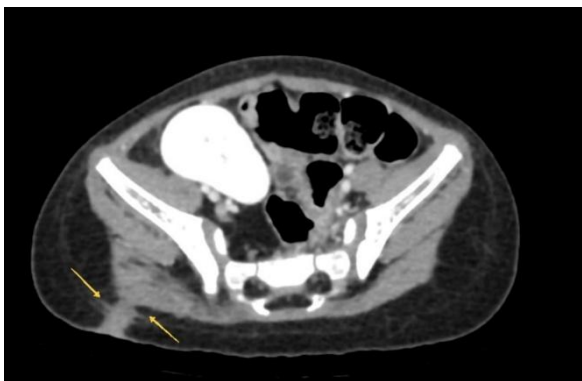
CT showing tract from skin extending into right pelvic cavity
